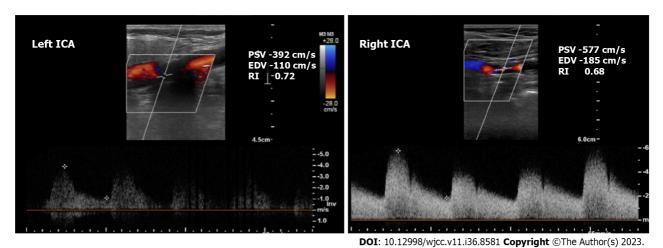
Preoperative carotid ultrasound duplex in case 4. Bilateral internal carotid artery stenosis of > 90%. EDV: End-diastolic velocity; PSV: Peak systolic velocity; RI: Resistance index; ICA: Internal carotid artery.
